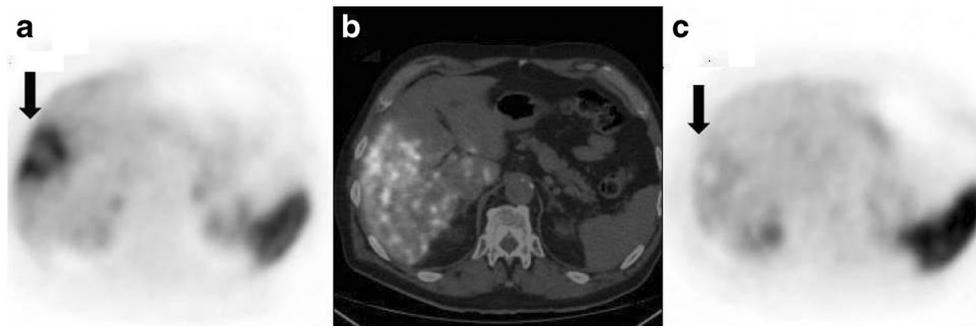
a ^{68}Ga -DOTANOC PET axial slice acquired before treatment shows intense tracer accumulation in a patient with a gross lesion of the right hepatic lobe (*arrow*). b Fused unenhanced CT slice and ^{90}Y PET transaxial slice acquired 2 h after administration of ^{90}Y microspheres shows accumulation of spheres in the tumour mass with a necrotic core
